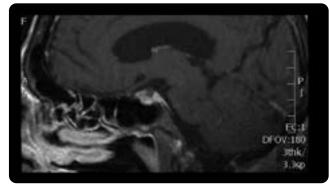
MRI, sagittal with T1 information with contrast medium: alteration in the morphology of the saddle, absence of adenohypophysis and interruption of the infundibulum in a patient with acromegaly is identified.
